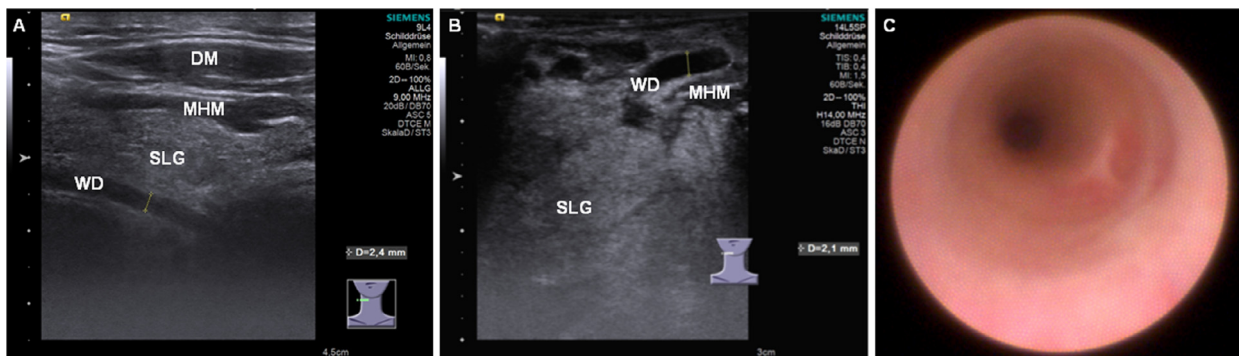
Ultrasound images of the right Wharton duct after application of ascorbic acid onto the floor of the mouth and sialendoscopic view. A, Transcutaneous ultrasonography, revealing duct congestion (2.4 mm); the cause of the obstruction is not visible. The papillary region usually cannot be imaged because of the dorsal sound extinction caused by the mandible. B, Transoral ultrasonography scan of the same patient, which depicts the congestion (2.1 mm) as well as the stenotic papilla, without any signs of a concrement. C, A sialolith, an inflammatory state, and other obstructive causes were excluded by using sialendoscopy after the surgical treatment. *DM*, digastric muscle; *MHM*, mylohyoid muscle; *SLG*, sublingual gland; *WD*, Wharton duct.
